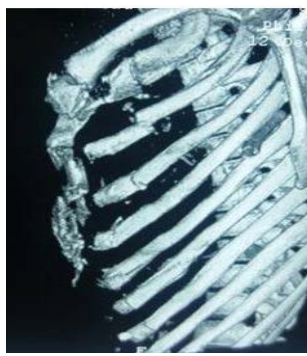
3D computed tomography scan of the patient's chest showing sternal fracture
